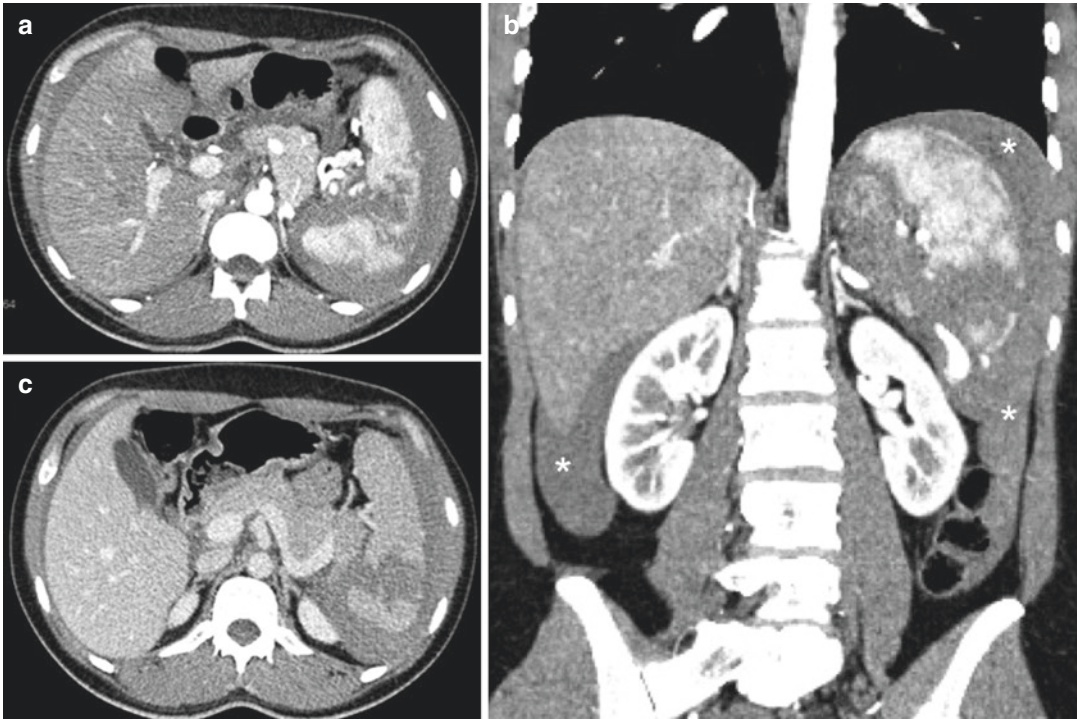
Grade 4b: This vascular CT study shows a splenic fracture associated with “large” hemoperitoneum (*asterisks*) in peri-hepatic, peri-splenic and both
